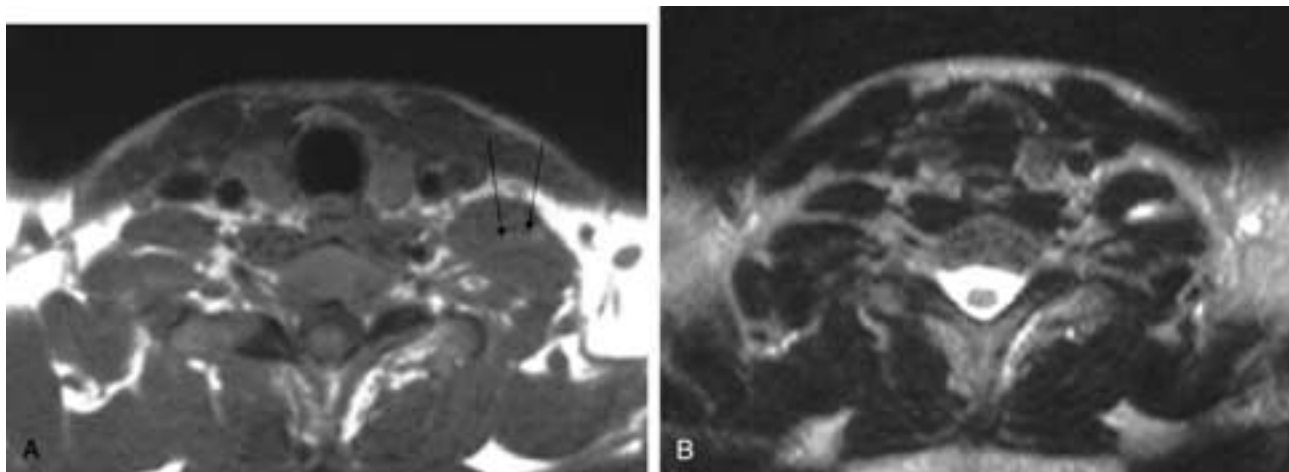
Neuritis. This is a patient after a scalene nerve block. Axial T1-weighted MR image (A) shows loss of fat between the left anterior and middle scalene muscle (*arrows*). Axial T2-weighted MR image (B) shows an area of increased signal in the same region. This is consistent with a neuritis.
